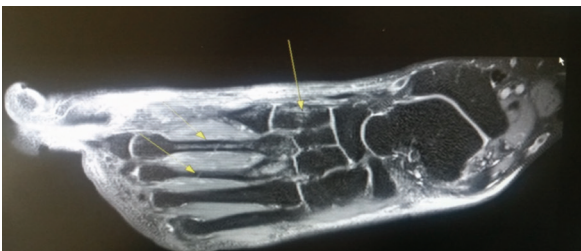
Magnetic resonance imaging on December 12, 2016 showed bone marrow edema at the medial cuneiform bone.
